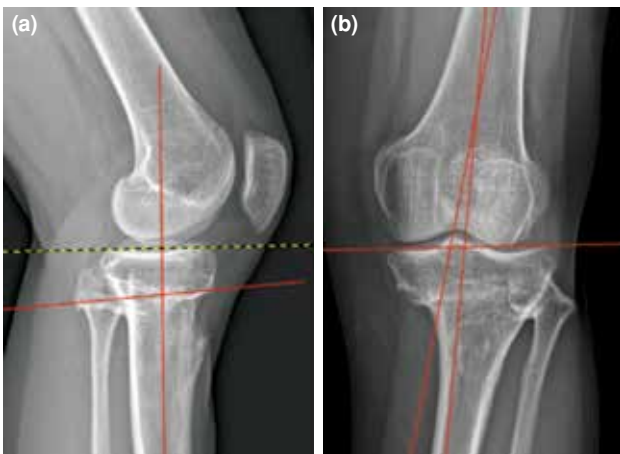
Seventh year follow-up radiographs show union without complication and restored tibial slope, coronal alignment and patellar height. (a) Posterior tibial slope is 7°, Canton-Deschamps index is corrected to 0.8 and (b) coronal alignment is 6° valgus.
